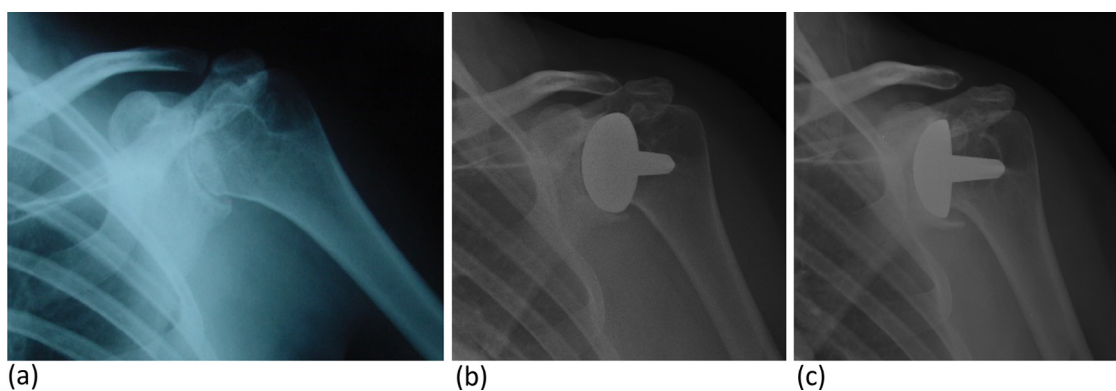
Anteroposterior radiographs demonstrate slowly progressive painless glenoid erosion in 1 patient: (a) preoperative, (b) 4 years postoperative, and (c) after 13 years.
